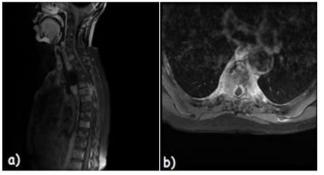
Spine MRI T1 post Gadolinium: bone metastasis with epiduritis.
